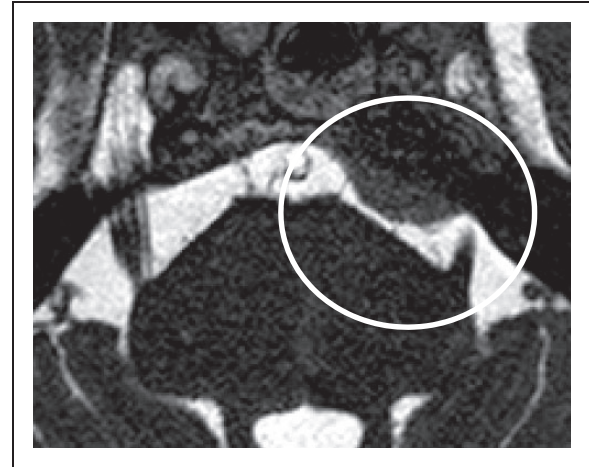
MRI in a patient with left-sided symptomatic trigeminal neuralgia. Balanced fast field echo sequence of the fossa posterior, axial plane at the level of the pons. The peripheral part of the left trigeminal nerve is displaced by a meningioma (both structures encircled).
